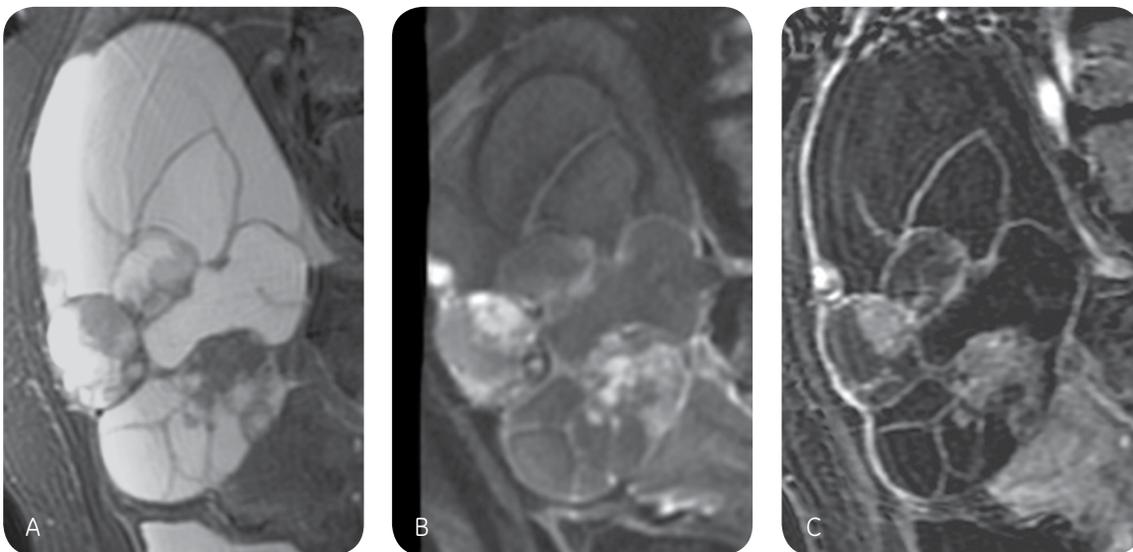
Sagittal T2w with fat suppression (A) shows a large ovarian multiloculated cystic mass with solid components. Sagittal FOCUS DWI (B) reveals high signal intensity solid cancer tissues within the cystic mass consistent with the sagittal 3D CE-T1w with fat suppression (C).
